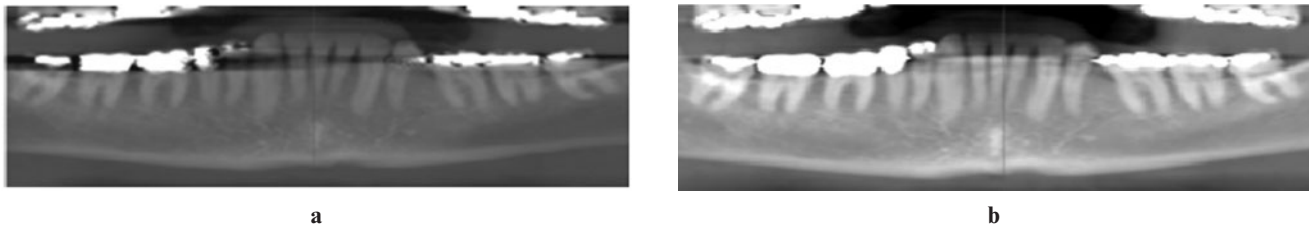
Application of the proposed method to the reconstruction of a panoramic radiograph-like image from dental CT data for forensic identification. (a) Panoramic reconstruction from dental CT data corrupted by metal artefacts. (b) Panoramic reconstruction using the same CT data as in (a) but after the application of the metal artefact reduction by sequential substitution (MARSS) algorithm
